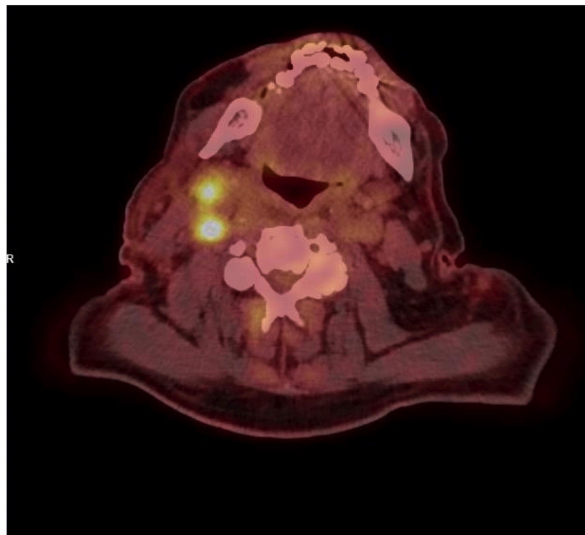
18 FDG PET-CT before and after teclistamab in RR POEMS syndrome
